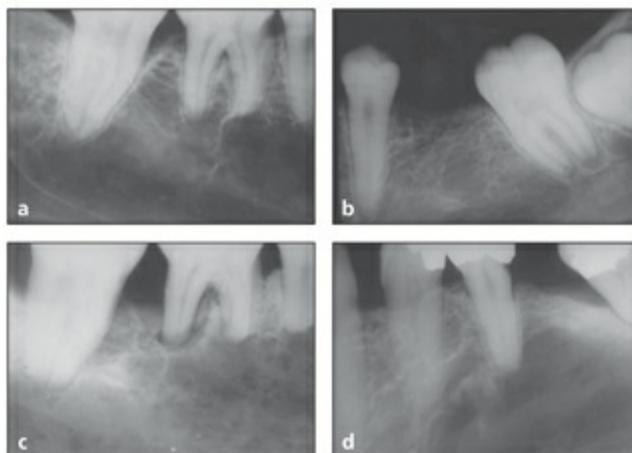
Radiographic presentation of Gaucher disease. (*a and b*) Uniform bilateral periapical radiolucency of the mandibular second premolars and first molars. (*c*) Twenty-year follow-up revealing evidence of periapical root resorption on the second premolar and first molar. The resorption only occurs in the apical portion of the roots. (*d*) Twenty-year follow-up of the contralateral side reveals less periapical root resorption. (Reprinted from Bender and Bender¹⁶³ with permission.)
